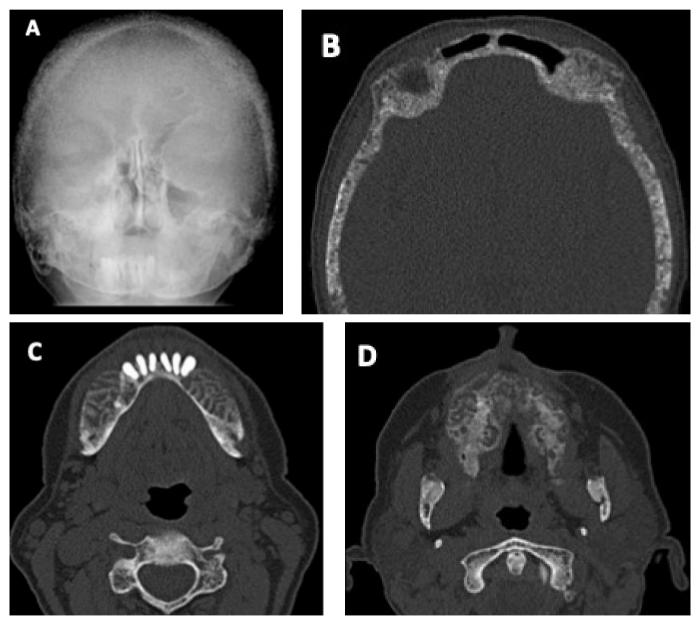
Waters X-ray showing altered radiopacity in the contours and volume of the facial and skull bones, as salt and pepper (A). The axial sections of the CT scan (B–D) reveal altered trabecular bone in the face, displaying a hypodense pattern, as well as an infiltrate in localized areas of the skull, with loss of continuity and integrity of the cortical bone.
